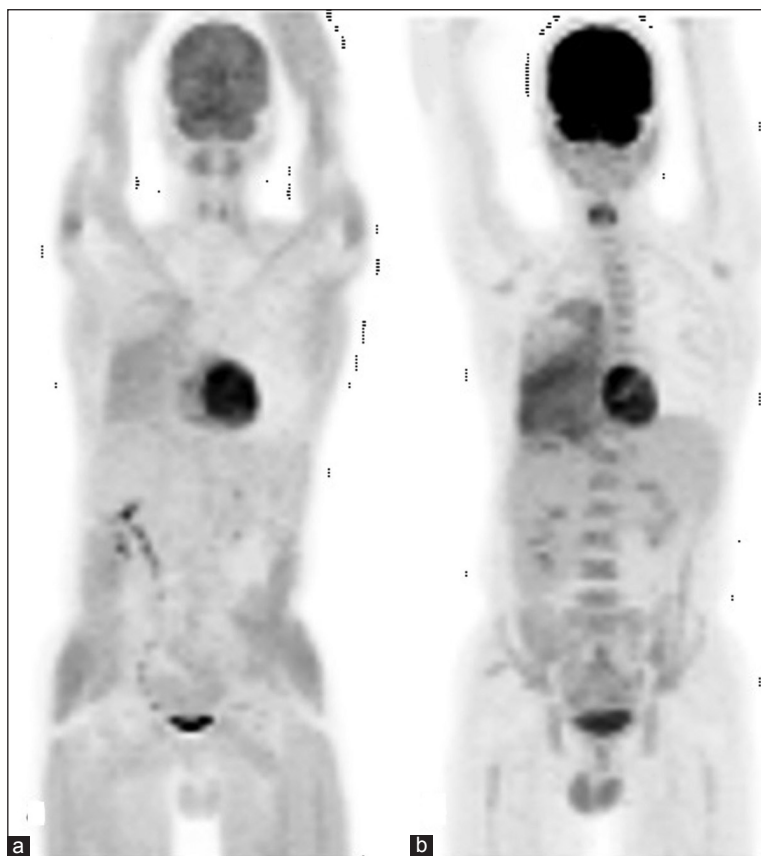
Positron emission tomography (PET) scan of a patient with diffuse large B cell lymphoma involving right lung done 3 h after intake of food. Maximum intensity projection image (a) diffusely increased uptake in muscles and faint uptake noted in the right lung (maximum standardized uptake value [$SUV_{max} = 3.1$]). However repeat study after adequate preparation and 6 h of fasting shows (b) increased F-18 fluoro-deoxy-glucose (FDG) uptake in the right lung lesion ($SUV_{max} = 12$). Learning point in this image is that inadequate fasting increases insulin mediated muscle uptake with a decrease in tumoral uptake of F-18 FDG that might lead to false negative interpretations and inadequate baseline study to evaluate response at a later date. This image highlights the importance of adequate fasting prior to F-18 FDG PET/computed tomography scan
